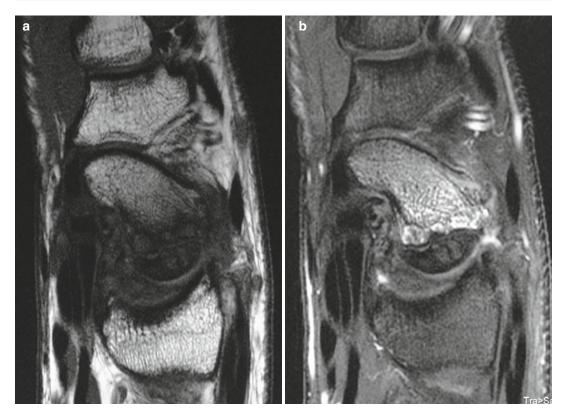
(a) MRI with signal loss in T1 imaging (b) MRI with no contrast enhancement demonstrating avascular bone
